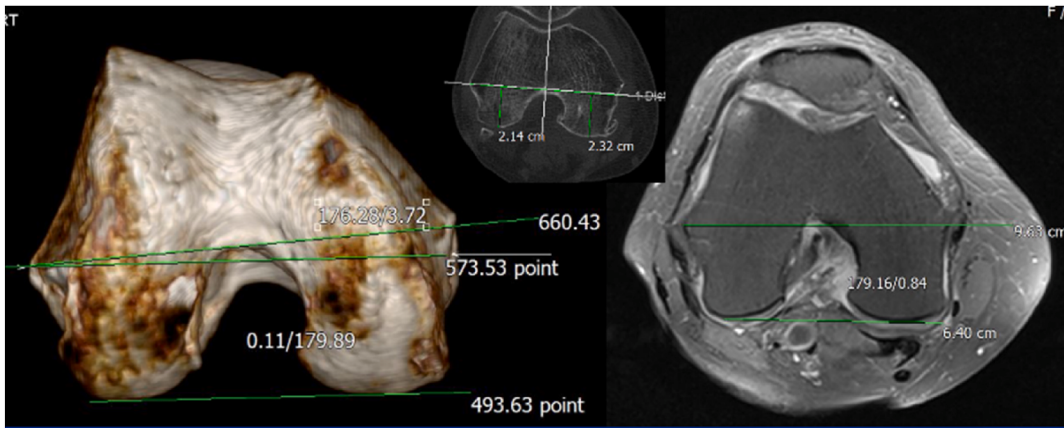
Measurement of trans-epicondylar axis using computed tomography scan and recheck on magnetic resonance imaging (MRI) scan.
